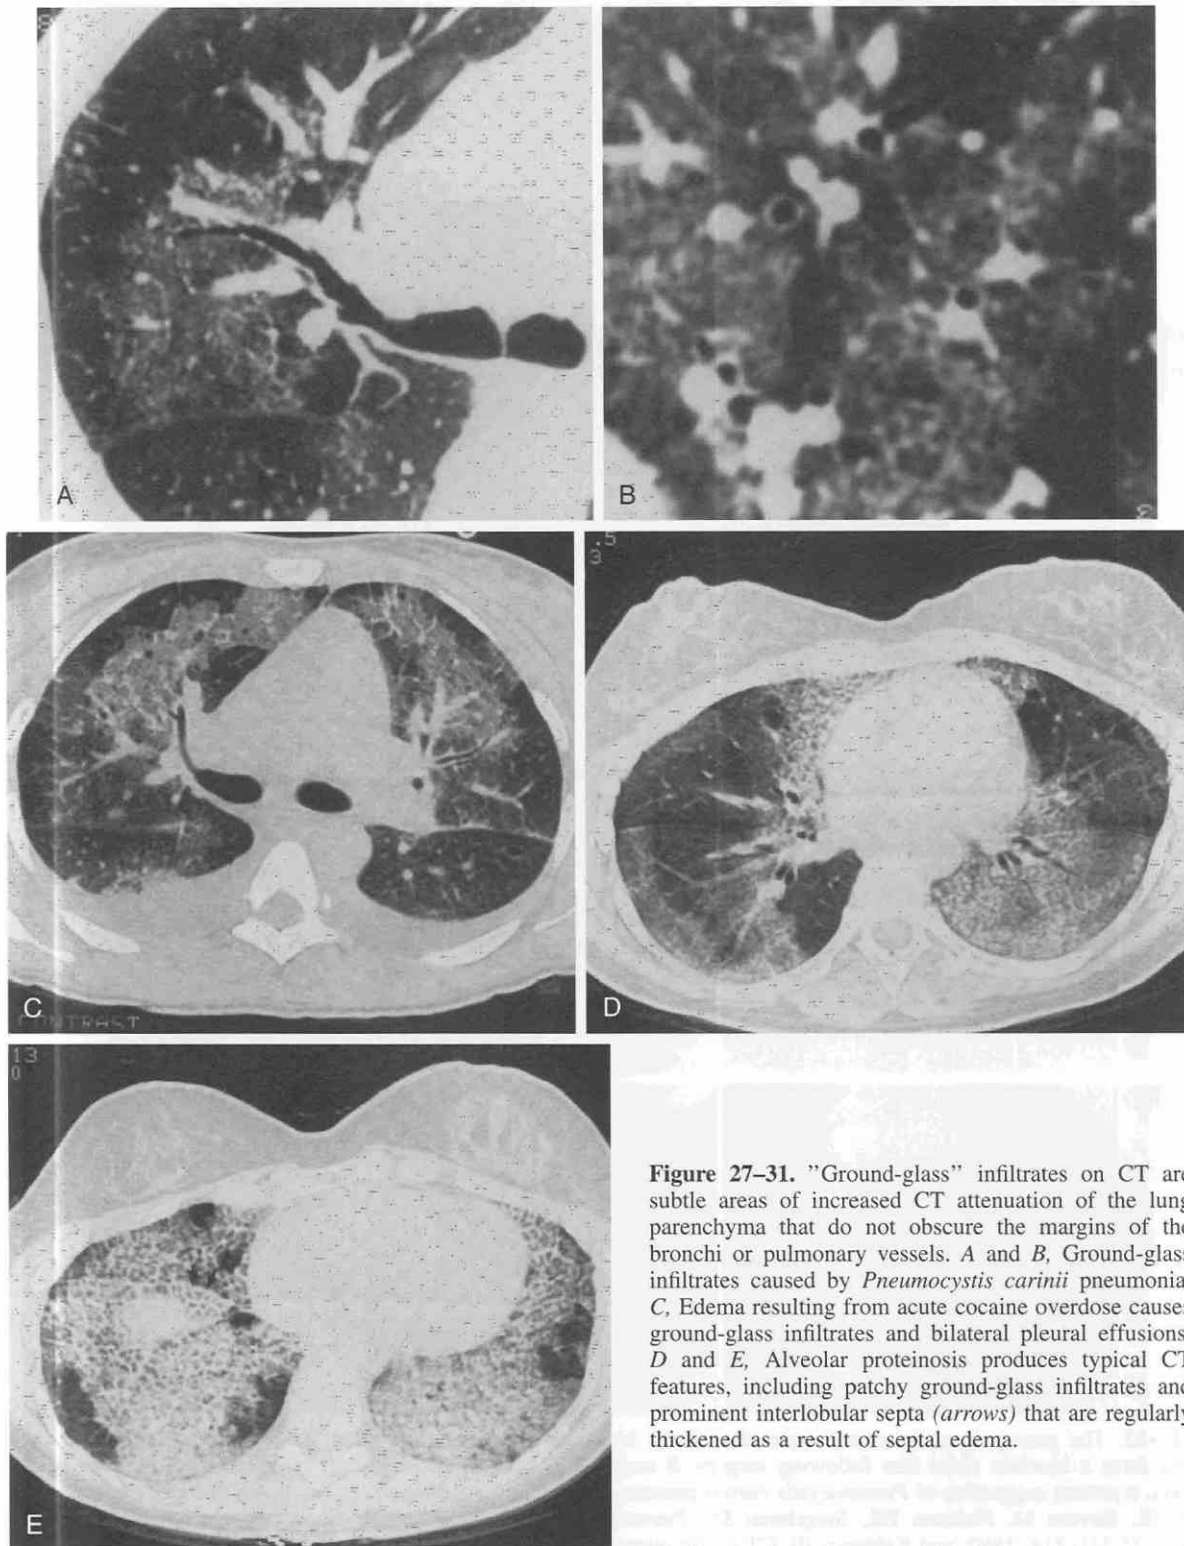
"Ground-glass" infiltrates on CT are subtle areas of increased CT attenuation of the lung parenchyma that do not obscure the margins of the bronchi or pulmonary vessels. A and B, Ground-glass infiltrates caused by *Pneumocystis carinii* pneumonia. C, Edema resulting from acute cocaine overdose causes ground-glass infiltrates and bilateral pleural effusions. D and E, Alveolar proteinosis produces typical CT features, including patchy ground-glass infiltrates and prominent interlobular septa (arrows) that are regularly thickened as a result of septal edema.
